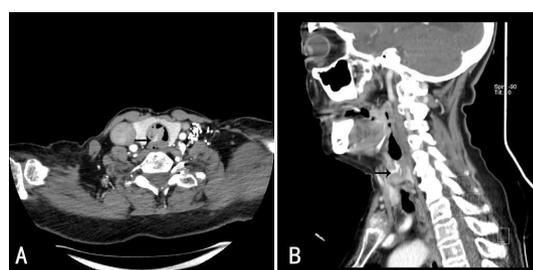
(A) Contrast-enhanced CT scan suggests a cauliflower-like lesion (1.5 cm×1.6 cm) at the level of the thyroid with an aberrant feeding artery in the stalk (black arrow). (B) Sagittal reconstruction image shows the artery inside the lesion (black arrow).
